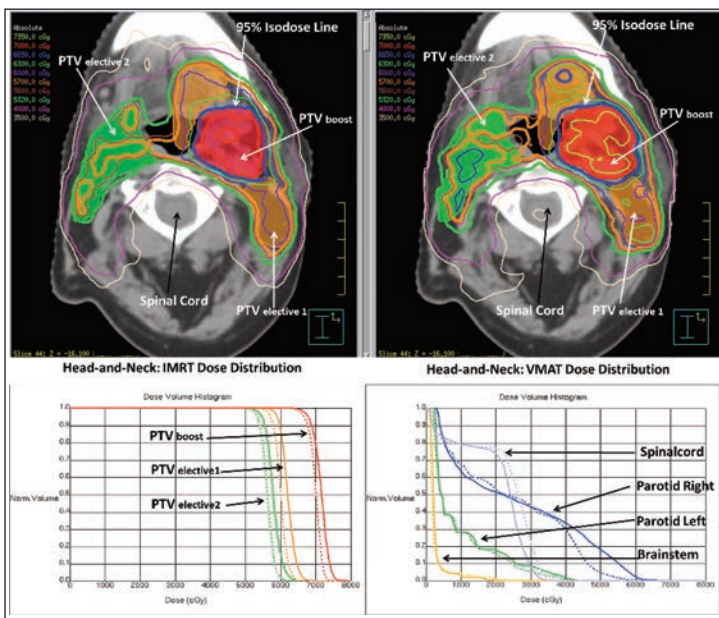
A representative case (Row-1) for head-and-neck dose distribution in specific computer tomography (CT) slice for intensity modulated radiotherapy (IMRT) and volumetric modulated arc-therapy. The thin green isodose line represents 90% of prescribed dose (PD) and thick blue isodose line represents 95% of PD covering whole of the PTVboost. The appropriate target coverage for both planning target volume (PTV)elective1 and PTVelective2 were achieved in terms of their PDs. Row-2 shows dose-volume histograms (DVH) for PTVs and organs at risk (OAR). Solid-lines represent VMAT and dotted-lines represent IMRT results.
